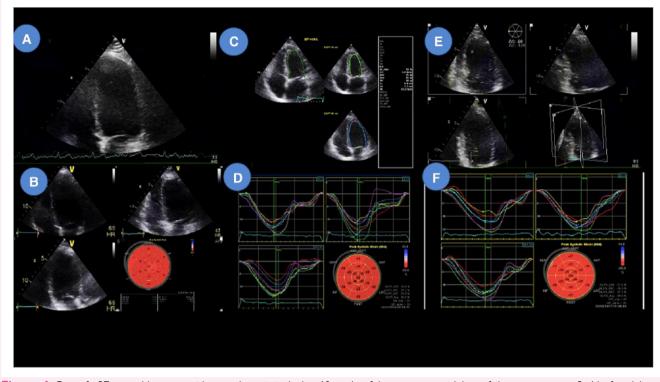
Case of a 37-year-old woman with pre-eclampsia in the last 10 weeks of the pregnancy with heart failure symptoms at 3–4 h after delivery. (A and B) TTE on the second day after delivery with dilated LV, LVEF 46%, and GLS –13.1%; (C and D) TTE at 1 month follow-up with LVEF 59% and GLS –20.1% (E and F). TTE, transthoracic echocardiography; LV, left ventricle; LVEF, left ventricle ejection fraction; GLS, global longitudinal strain.
